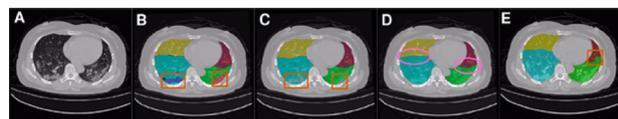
Qualitative assessment on a CT image (coronacases_010) with severe pathology: (a) ct; (b) model output after choosing the largest connected; (c) largest connected component with lung template; (d) final post-processing by hole fillings; and (e) output by Lungmask model. Locations where the method got it right are represented by a circular region. Locations where the method made an error are represented by a rectangular region.
